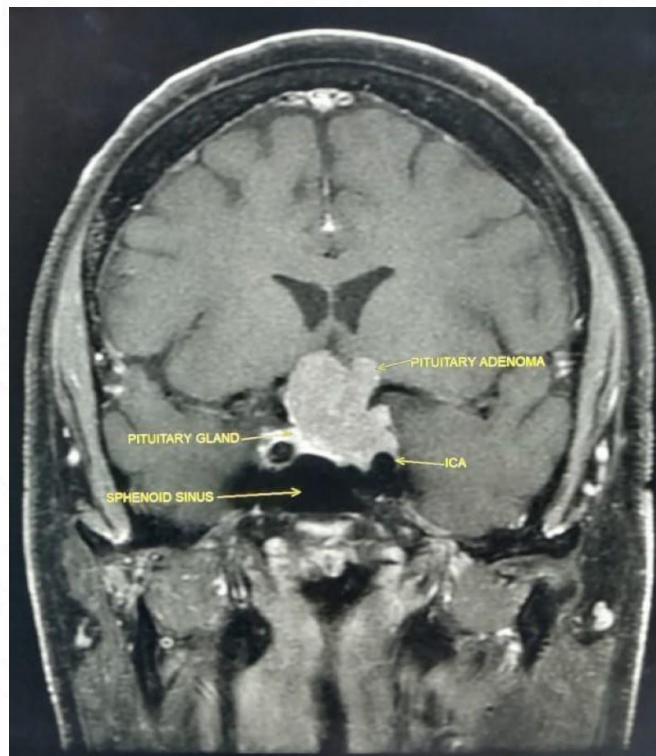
shows the MRI - coronal T1 post-contrast image of our patient showing a pituitary adenoma
